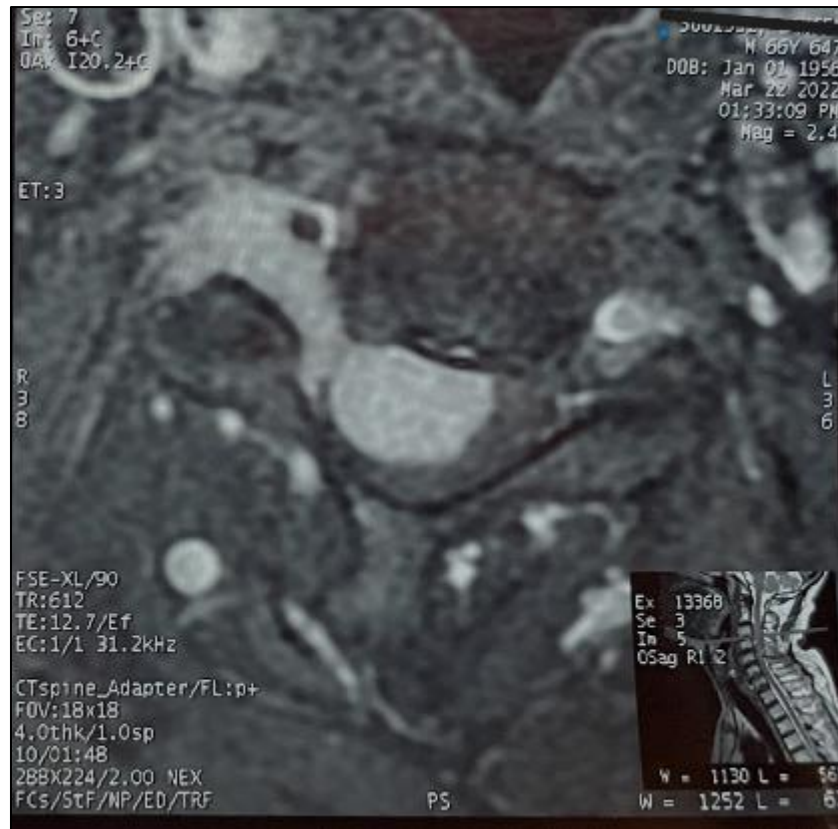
Axial gadolinium-enhanced T1-weighted MRI showing lesion enhancement and foraminal extension
